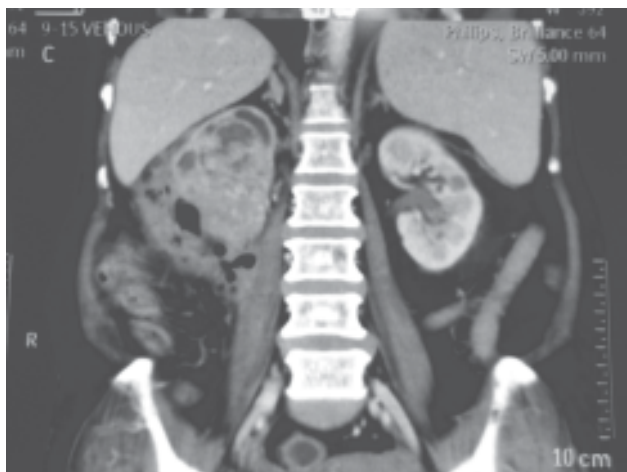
Computed tomography revealed hypervascular right renal mass showing large area of necrosis suspicious of renal cell carcinoma, xanthogranulomatous pyelonephritis; with dilated pelvicalyceal system of the right kidney and renal abscess formation extending to perinephric and subcutaneous tissue plane.
